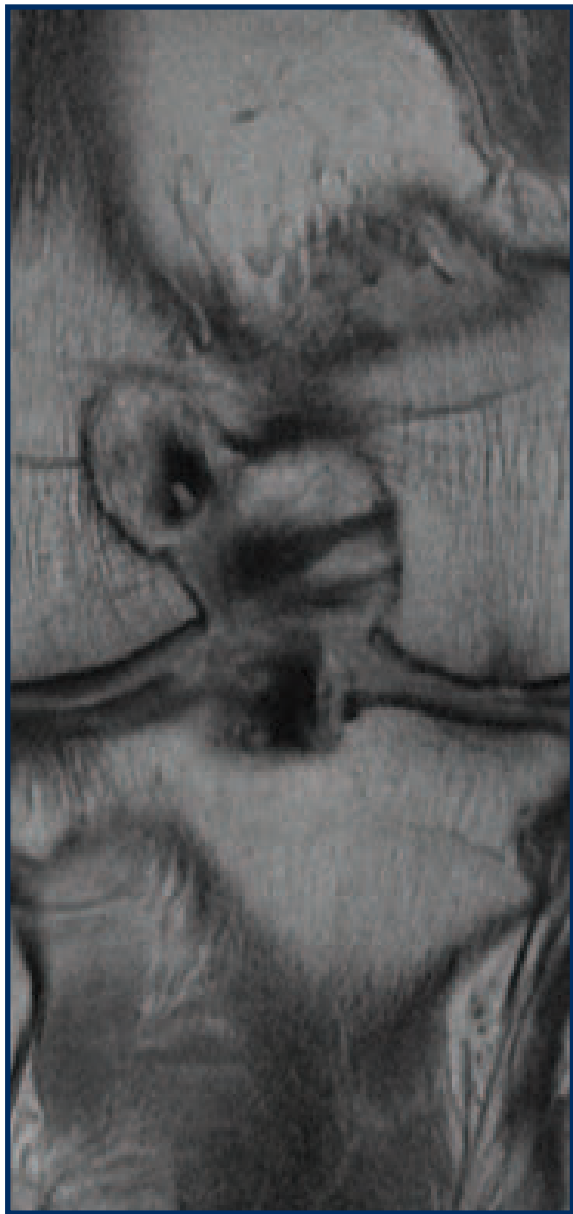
Pre-operative MRI showing femoral ACL tunnel widening.
